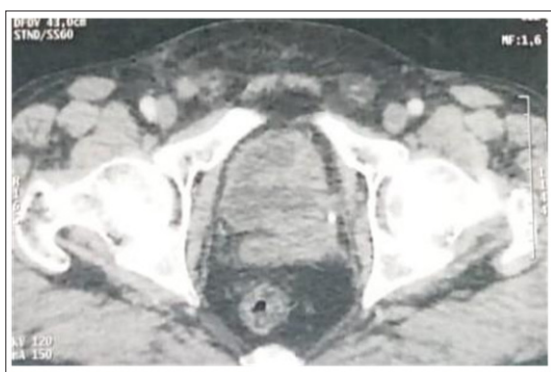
On the follow-up CT scan, the left anterolateral bladder tumor increased in size: 33 x 42 mm vs 22.9 x 35.4 mm.
